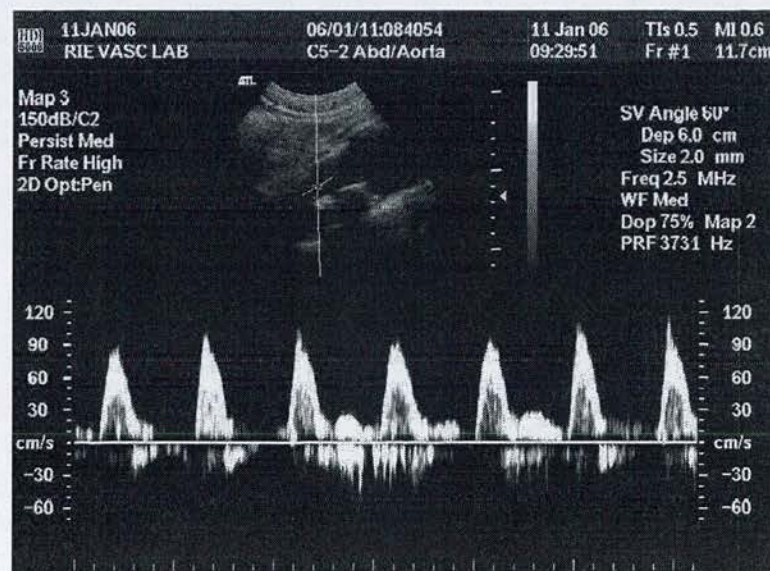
Example of a Doppler Spectrum with B-mode image for positioning.
